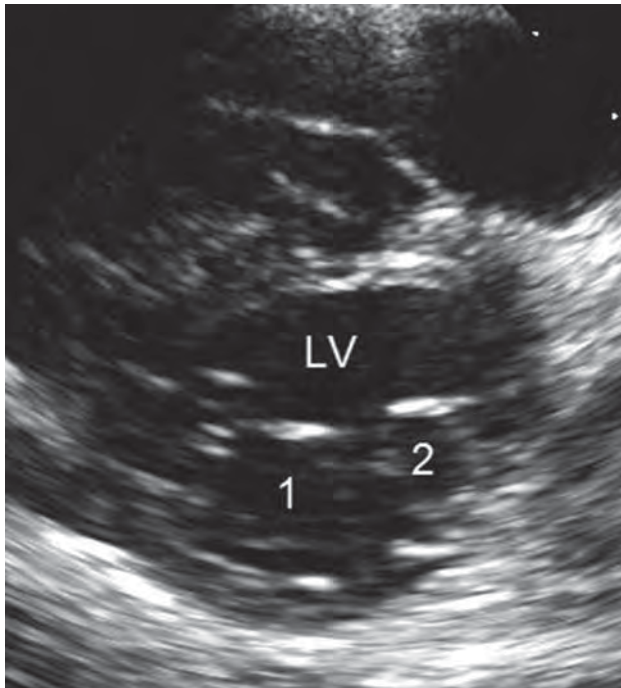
Parasternal short-axis view showing the two orifices (labeled 1 and 2) of the double orifice mitral valve. LV, left ventricle.
